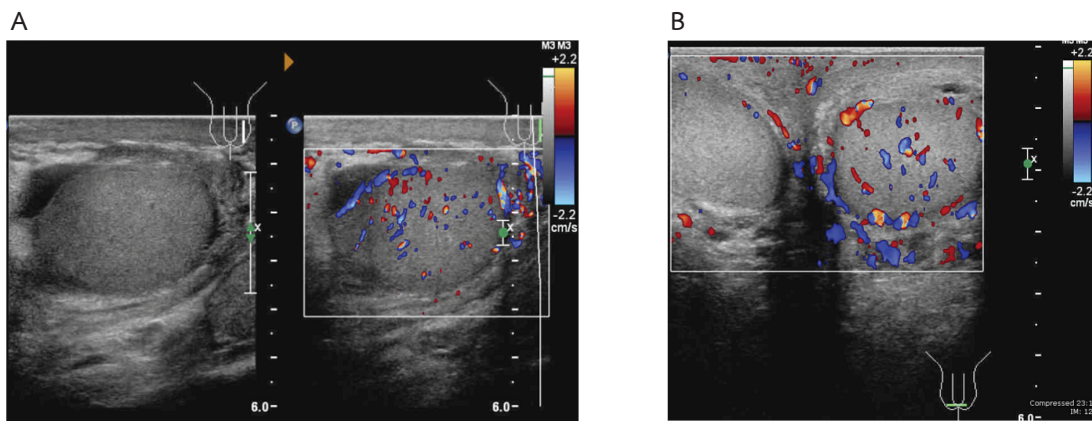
Left epididymo-orchitis. (A) Gray-scale and color Doppler sonography show normal echogenicity with increased flow of left testis. (B) Color Doppler sonography shows increased flow of left testis as compared to the normal right side. Left scrotal skin thickening is also shown.
